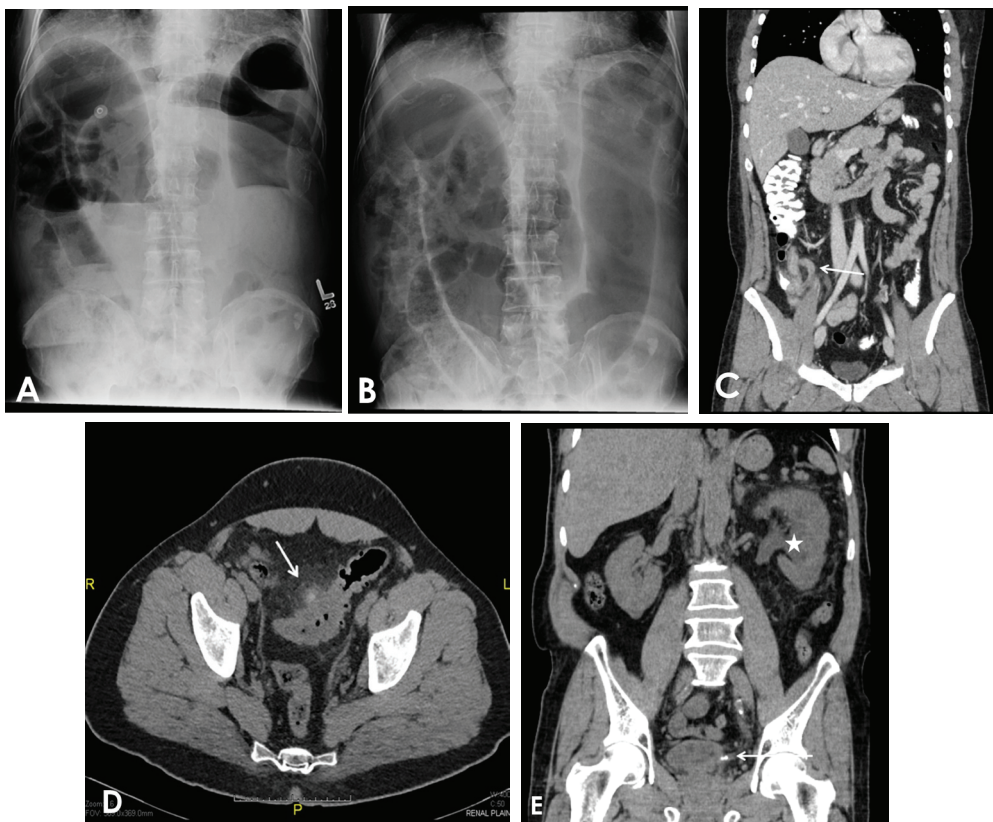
A photography showing the A) erect and B) supine abdominal radiograph demonstrating a large bowel distension with large air-fluid level suggestive of distal large bowel obstruction in a 58-year-old male. No evidence of bowel perforation. Sigmoid cancer causing the obstruction was diagnosed by contrast enhanced CT. C) An enhanced coronal image of the abdomen and pelvis with oral contrast, demonstrating a thick and inflamed appendix (arrow) with soft tissue stranding suggestive of acute uncomplicated appendicitis. D) CT showed an acutely inflamed sigmoid diverticulum (arrow), with soft tissue stranding in a 35-year-old male with left lower abdominal pain. E) An unenhanced coronal low dose CT scan of the abdomen and pelvis, demonstrating 2 obstructive stones at the distal end of the left ureter (arrow) causing sever left hydronephrosis (star).
